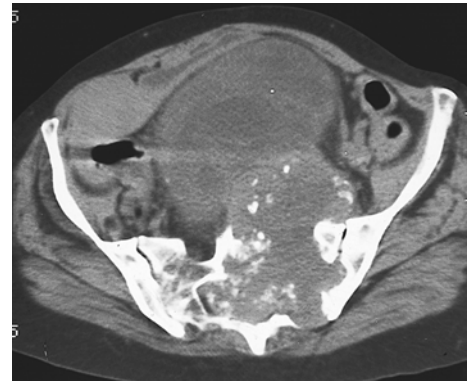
CT scan demonstrates the erosion of sacrum and sacral canal. (4.24.84).
